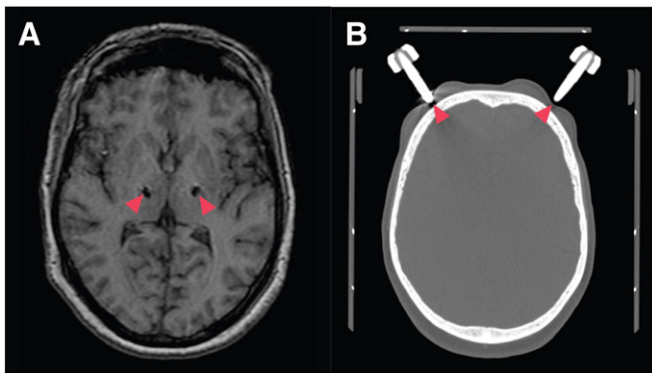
Registration Landmark Localization. Localization of DBS electrode tracts on post-operative MRI (A) and stereotactic frame pins on pre-operative CT (B). These landmarks assist with registration to the intraoperative fluoroscopic image. Red arrows designate electrode locations and pin tips.
